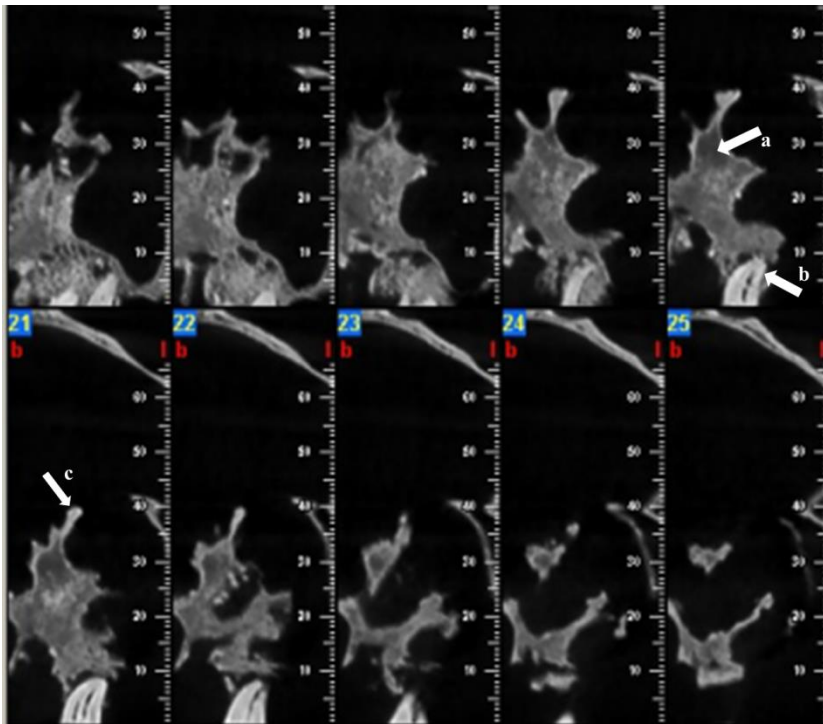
CBCT scan of maxillary sinus lesion. Note areas of radiolucency (a) and sclerosis (c), and the intimate association between maxillary molar root apices (b) and the base of the lesion.
